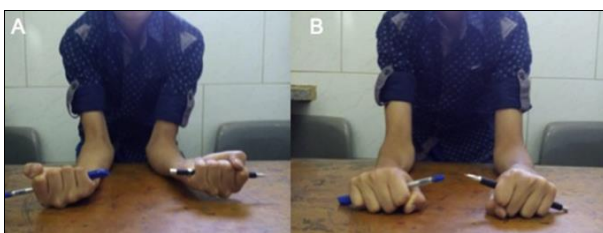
Clinical picture showing forearm supination-pronation forearm range in patient whose radiographs are shown in, a) Maximum supination, b) Maximum pronation
